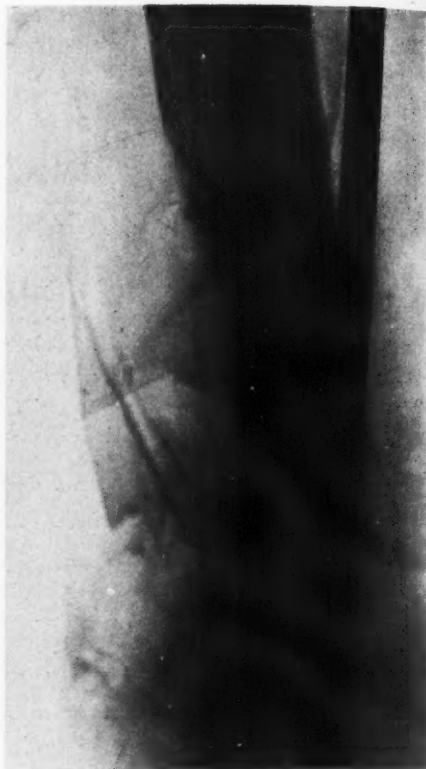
Roentgenogram showing diffuse cystic destruction in the lower shaft of a femur from carcinoma of the stomach, metastasizing to the bone. Path. No. 39,012.
